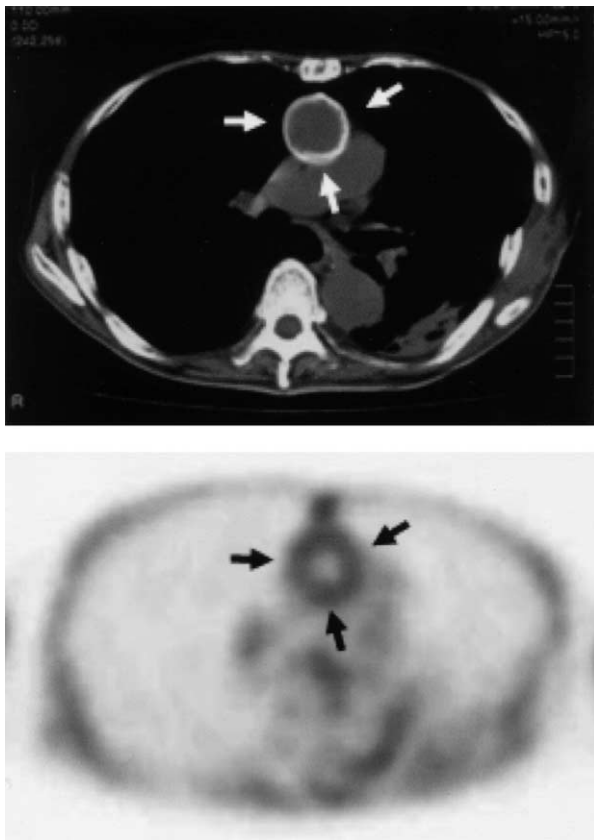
Example of false-positive findings on computed tomography (CT) and a true-negative result on fluorodeoxyglucose (FDG) positron emission tomography in a patient without graft infection. An exophytic perigraft fluid density is seen (*white arrows*) at the prosthetic aortic arch on a contrast-enhanced CT image. At this site, there is no accumulation of FDG at all (*black arrows*).
